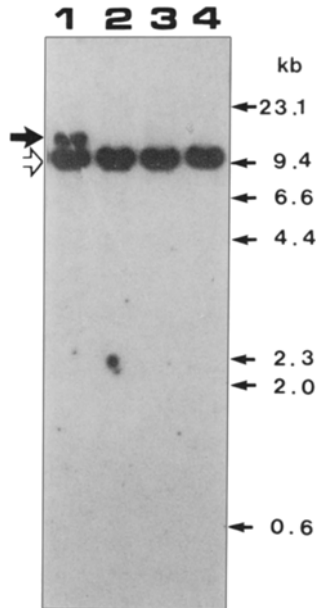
Southern blot analysis of genomic DNA from a true hermaphrodite, control female and control male, using a 422-bp SRY fragment and a 4.0 kb fragment of the peptidase D gene (Tanoue *et al.*, 1990). A 10 μ g DNA sample was digested with *RcoRI*, electrophoresed on 0.8% agarose gel, and transferred to a nitrocellulose filter. The filter was first hybridized with the 422-bp SRY fragment labeled with 32 P. The filter was washed and exposed to X-ray film for 7 days. The same filter was re-hybridized with the 4.0 kb fragment of peptidase D gene, as an internal standard. The SRY gene is indicated by a black arrow and peptidase D gene by a white arrow. Molecular weight marker (λ /*HindIII*) is shown at right side. Lane 1, leukocytes from a control male; lane 2, ovotestis from the patient; lane 3, leukocytes from the patient; lane 4, leukocytes from a control female.
